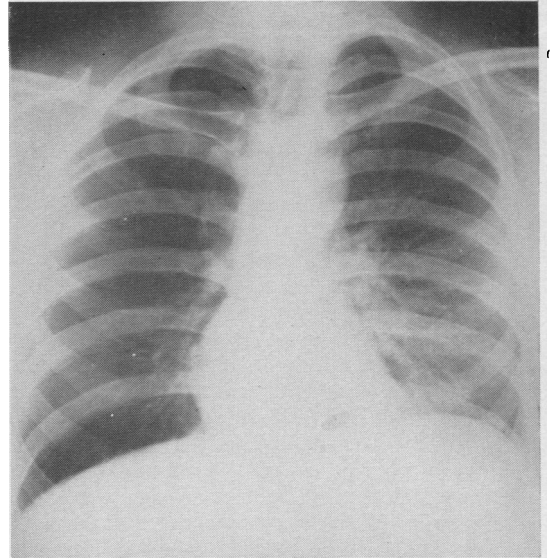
Same patient as in Fig. 1, radiograph taken in expiration.
